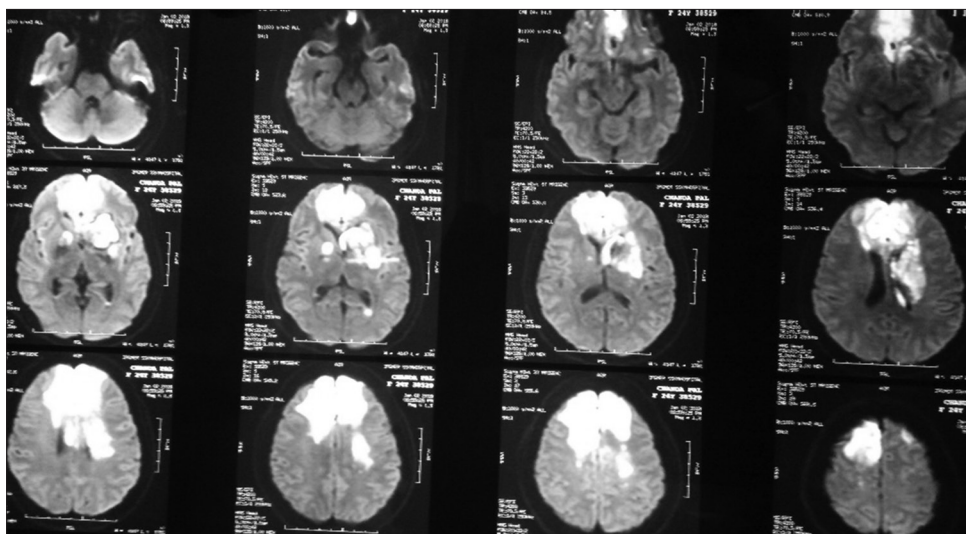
Magnetic resonance imaging of the brain, after the third episode of headache, revealed widespread diffusion restriction, mainly in bilateral medial frontal (parasagittal) region
